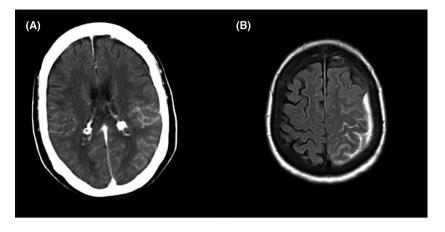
(A) CT scan showing hyperintensity in the left temporoparietal area. (B) Brain MRI: showing hyperintensity of signal in the left perirolandic and parieto-occipital area.
